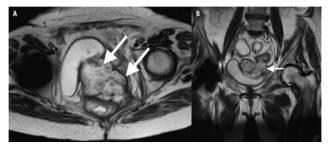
MRI axial sequence with axial (A) and coronal (B) T2 information. Multiloculated cystic pelvic lesion (white arrows) with thick walls and septa involving the rectal wall, vaginal vault and posterior wall of the bladder, corresponding to a case of a patient with tumor recurrence.
